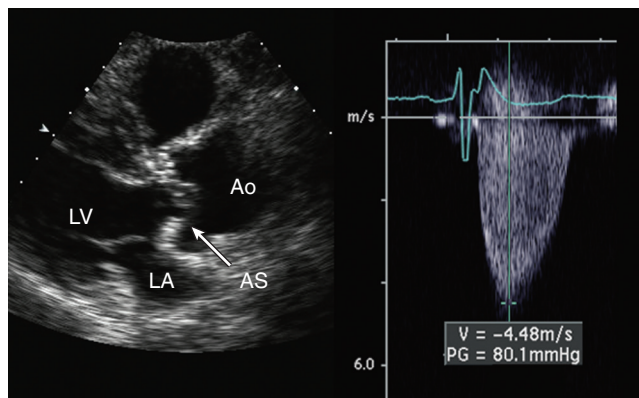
■ Severe aortic stenosis (AS), with thickened, calcified aortic valve leaflets on the parasternal long axis view. On continuous Doppler imaging across the aortic valve, the peak velocity (V) is 4.5 m/s, corresponding to a peak gradient (PG) of 80 mm Hg, using the simplified Bernoulli equation. Ao, Aorta; LA, left atrium; LV, left ventricle.
